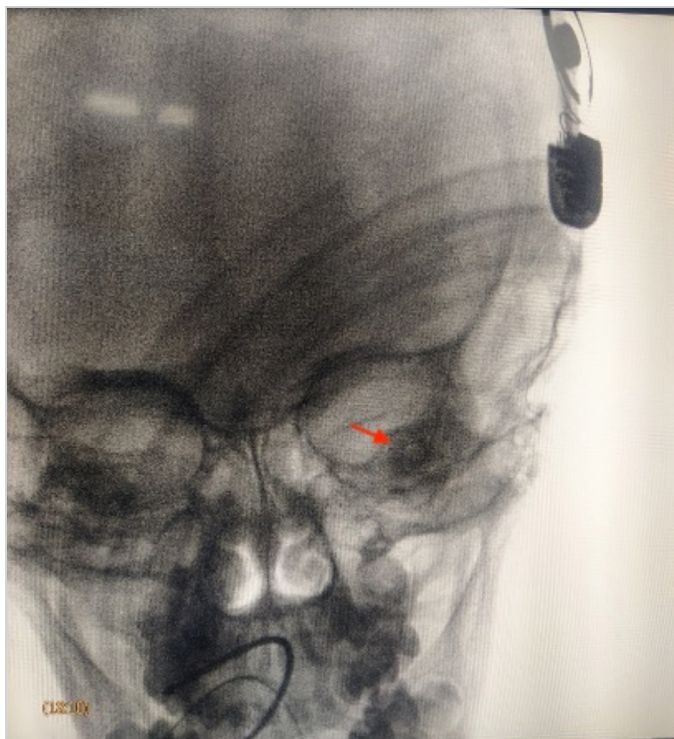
Postoperative X-ray of skull with trans-orbital view showing the position of electrode
